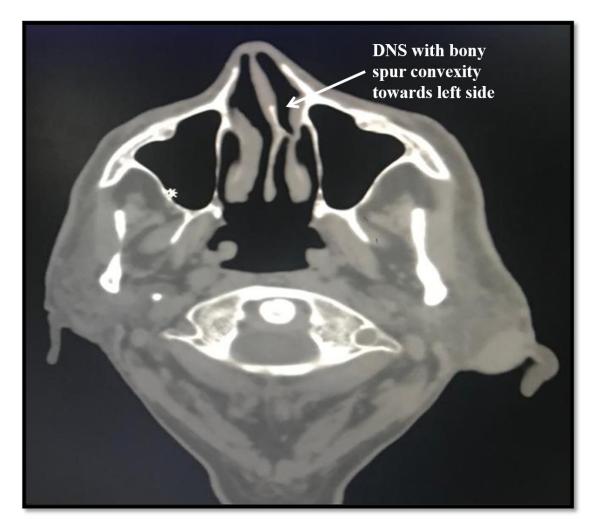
Axial view of CT-PNS showing deviated nasal septum (DNS) with bony spur convexity towards left side in symptomatic subject of sinusitis
